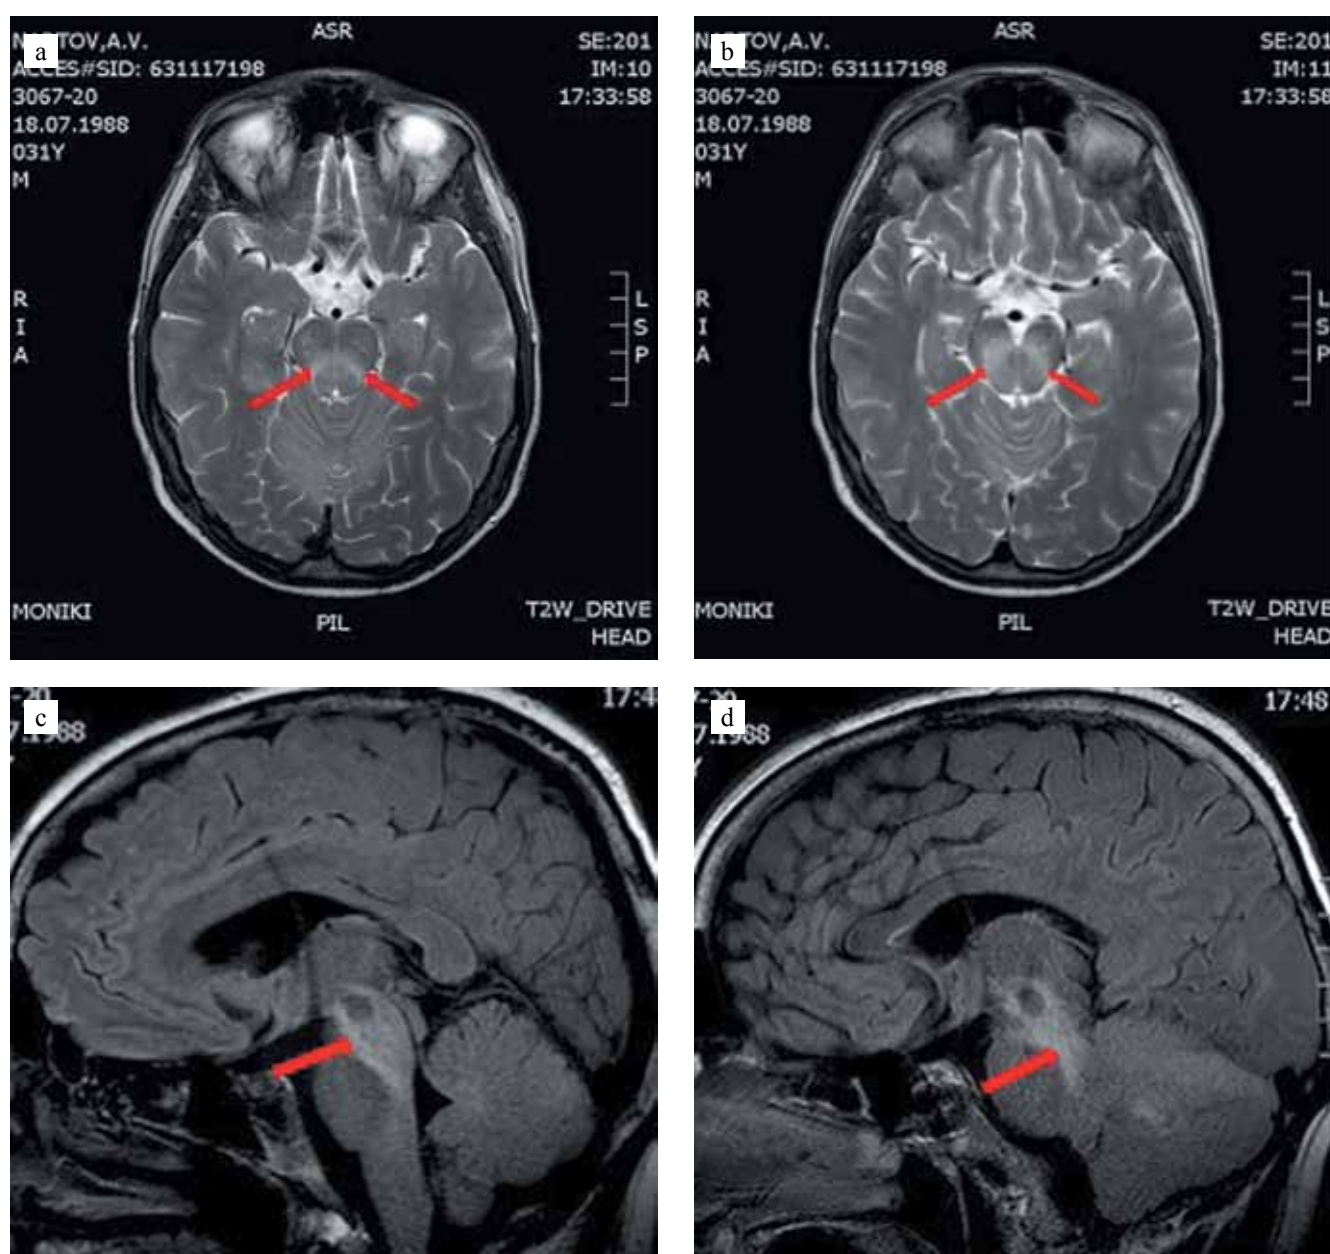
Non-contrast-enhanced magnetic resonance imaging of the brain of patient N.: a, b. T2-weighted (axial) images of the brain; c, d. diffusely weighted (sagittal) images of the brain. Symmetrical enhancement of the MR signal from the midbrain and thalamus (shown by arrows)
